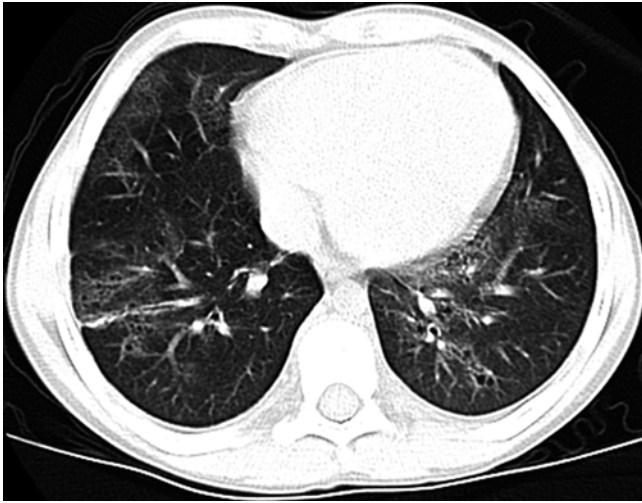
Nonspecific interstitial pneumonia in an 11-year-old boy who presented with dry cough, shortness of breath, and fatigue. Axial lung window CT image shows a combination of ground-glass opacification and traction bronchiectasis
